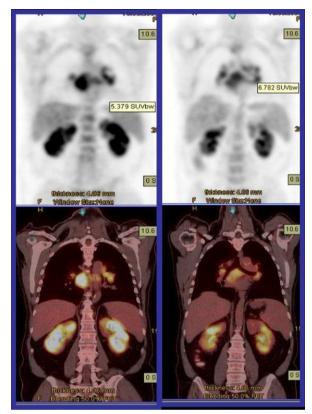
FDG uptake in mediastinal lymph nodes in a patient with granulomatous disease.
